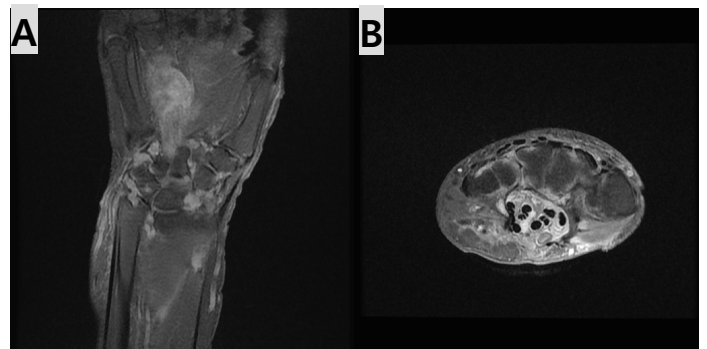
Preoperative magnetic resonance imaging of the left hand. (A) Coronal image demonstrating a diffusely infiltrative soft tissue lesion extending along the flexor tendon sheaths from the wrist to the palm and proximal digits. (B) Axial image showing encasement of multiple flexor tendons with extension into the carpal tunnel, resulting in crowding of the surrounding neurovascular structures.
